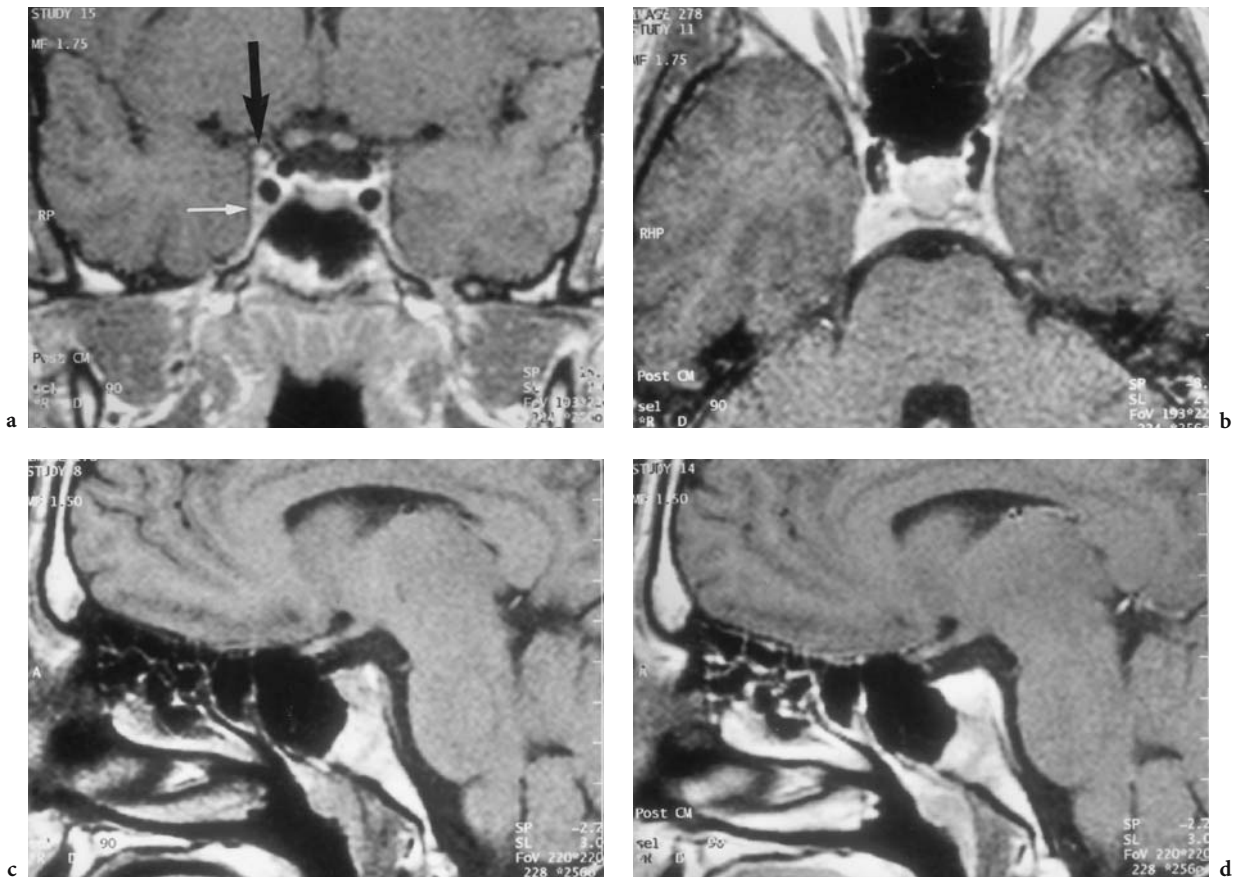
A 20-year-old man with acute right N VI paresis persisting for 14 days. Diagnosis: suspected meningioma of the right lateral clivus (including Dorell canal). T1-weighted MRI: a Coronal contrast-enhanced view of the cavernous sinus where the location of the right abducent nerve is distinguished in the cavernous sinus (*white arrow*). Note a small, round structure at the upper end of the right cavernous sinus (*black arrow*) corresponding to the upper end of the tumor. b Axial contrast-enhanced image demonstrating a slight asymmetry of the cavernous sinus configuration of the right side. c Right paramedian, sagittal native view, lateral to the pituitary gland with a slightly hyperintense mass and thickening of the dura. d Corresponding contrast-enhanced image, showing enhancement of both the mass and the dura of the clivus. The patient was transferred for stereotactic radiation but lost to follow-up
